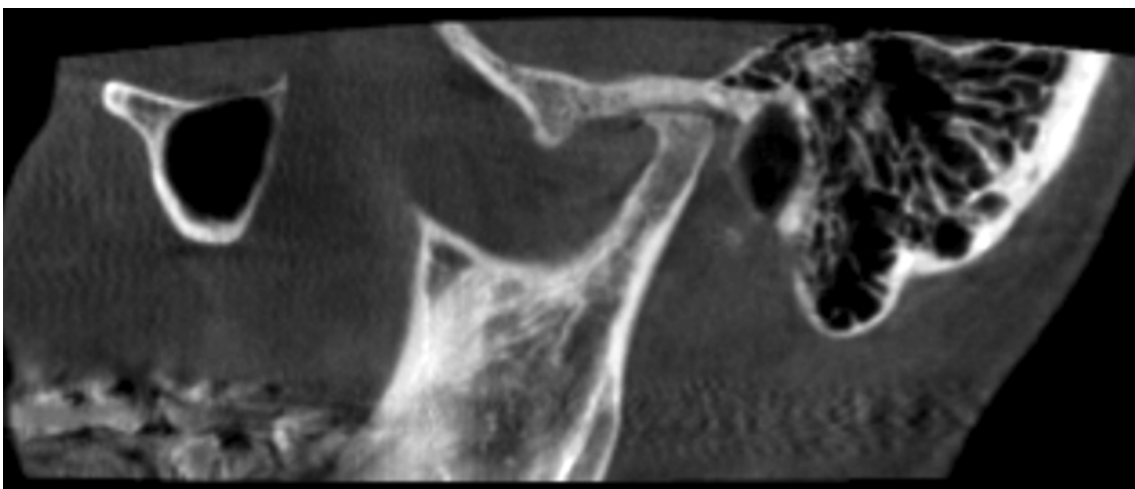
Female, 72 years. Oblique sagittal CBCT view shows deformed joint with surface flattening of condyle and fossa/eminence, surface erosion and subcortical sclerosis in the fossa, interpreted as osteoarthritis. CBCT, cone beam CT.
